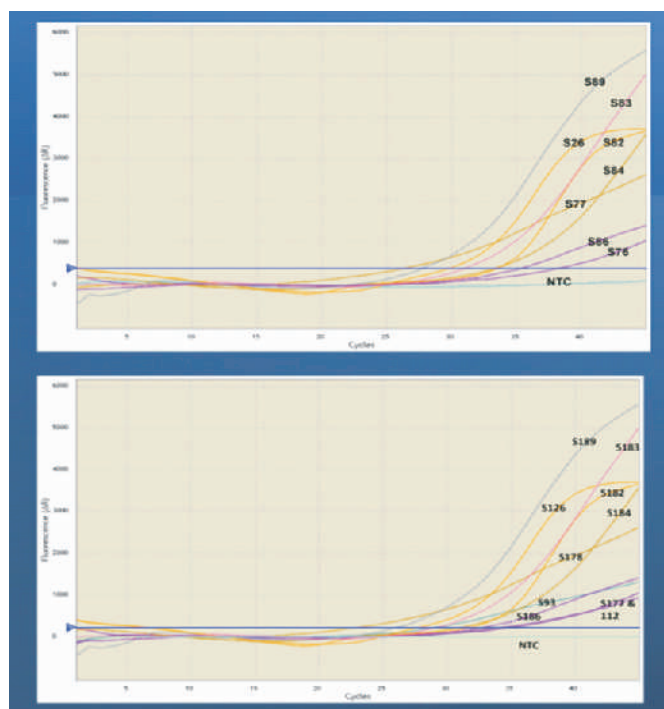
Optics graph shows RT-PCR of human Rhinovirus A results using FAM fluorescent dye. According to (threshold=417.525):- positive samples no. are 15, 26, 76, 77, 82, 83, 84, 86, 89, 93, 111, 126, 177, 178, 182, 183, 184, 186, and 189 with CT values of 27.68-33.66. No amplification in no template control (NTC).
